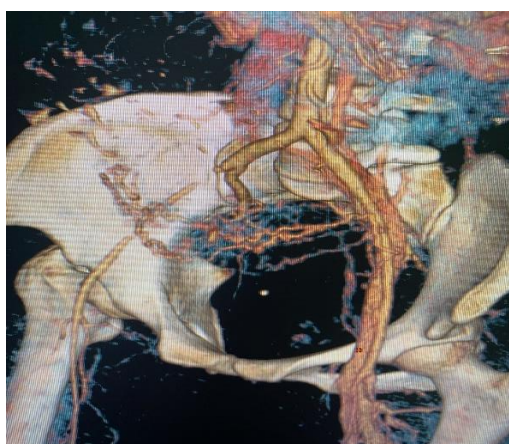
CT angiography of the aorta and both lower limbs revealing partial occlusion of the right external iliac artery with downstream patency.
